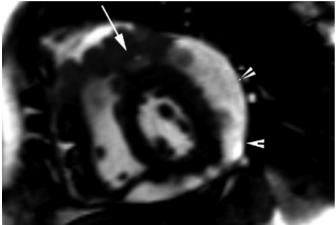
Axial cine MRI using balanced steady state free precession (b-SSFP) at the level of the mid left ventricle demonstrating moderate circumferential pericardial effusion (arrow heads) and metastatic mass involving the anterior wall and infiltrating the anterior descending coronary artery (arrow).
